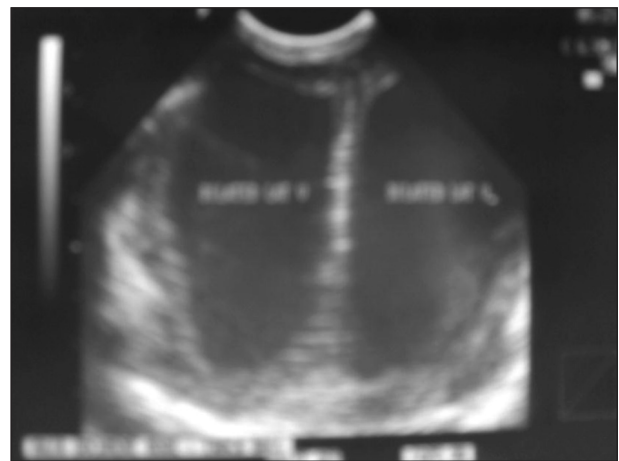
Brain sonography showing grossly dilated lateral ventricles
